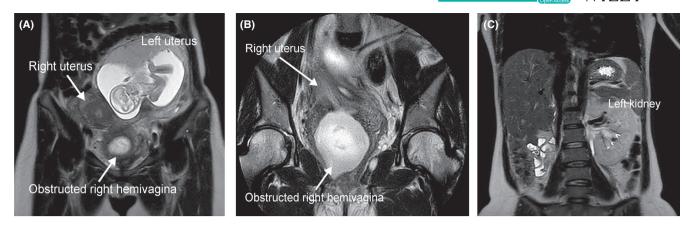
T2-MRI of the abdomen at 17 wk of gestation. A, the gravid left uterus with a residing fetus. B, right uterus connected to the fluid-filled pelvic mass at the level of upper part of the right vagina, consistent with an obstructed right hemivagina with a pyocolpos. C, presence of one hypertrophic kidney on the left only, confirming right renal agenesis
